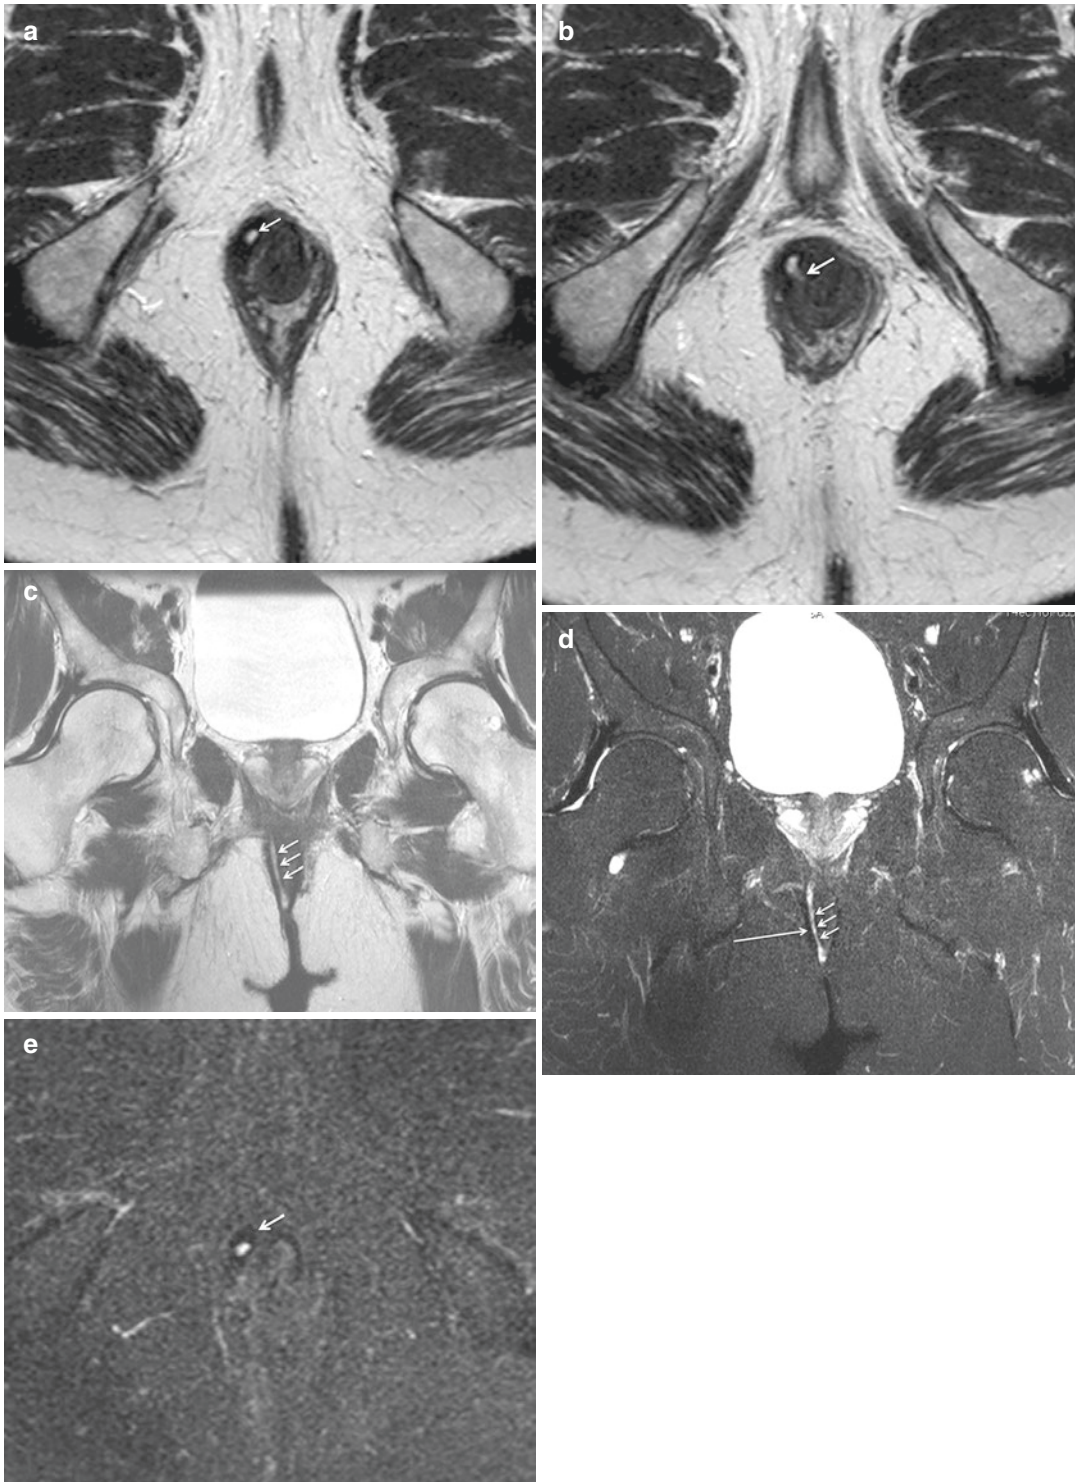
Inter-sphincteric fistula. Axial-oblique T2-weighted TSE images (a) show inter-sphincteric fistula at 11 o'clock (arrow). In a more cranial image (b) the internal opening is demonstrable (arrow). Coronal-oblique T2-weighted TSE images performed without (c) and with fat saturation (d) show right inter-sphincteric
